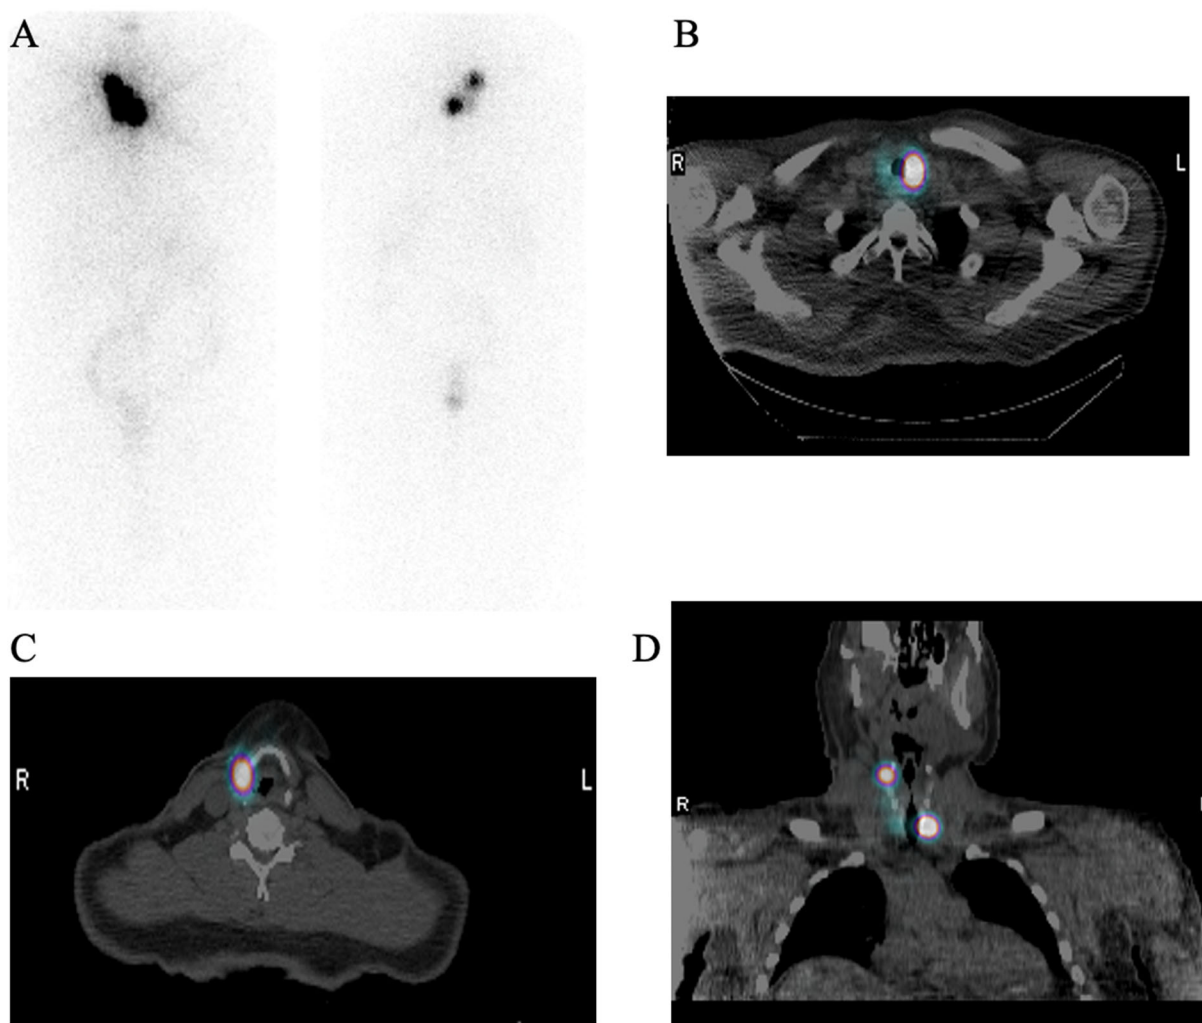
Case 3, Post-therapy Scan of Dialysis Patient. Left (A): Whole-body post ^{131}I scan. B-D: SPECT/CT imaging of the neck and upper chest. These images show no evidence of distant metastatic disease. However, they did find three discrete regions of tracer activity within the neck, consistent with radioiodine avid tissue, likely residual thyroid tissue after thyroidectomy.
